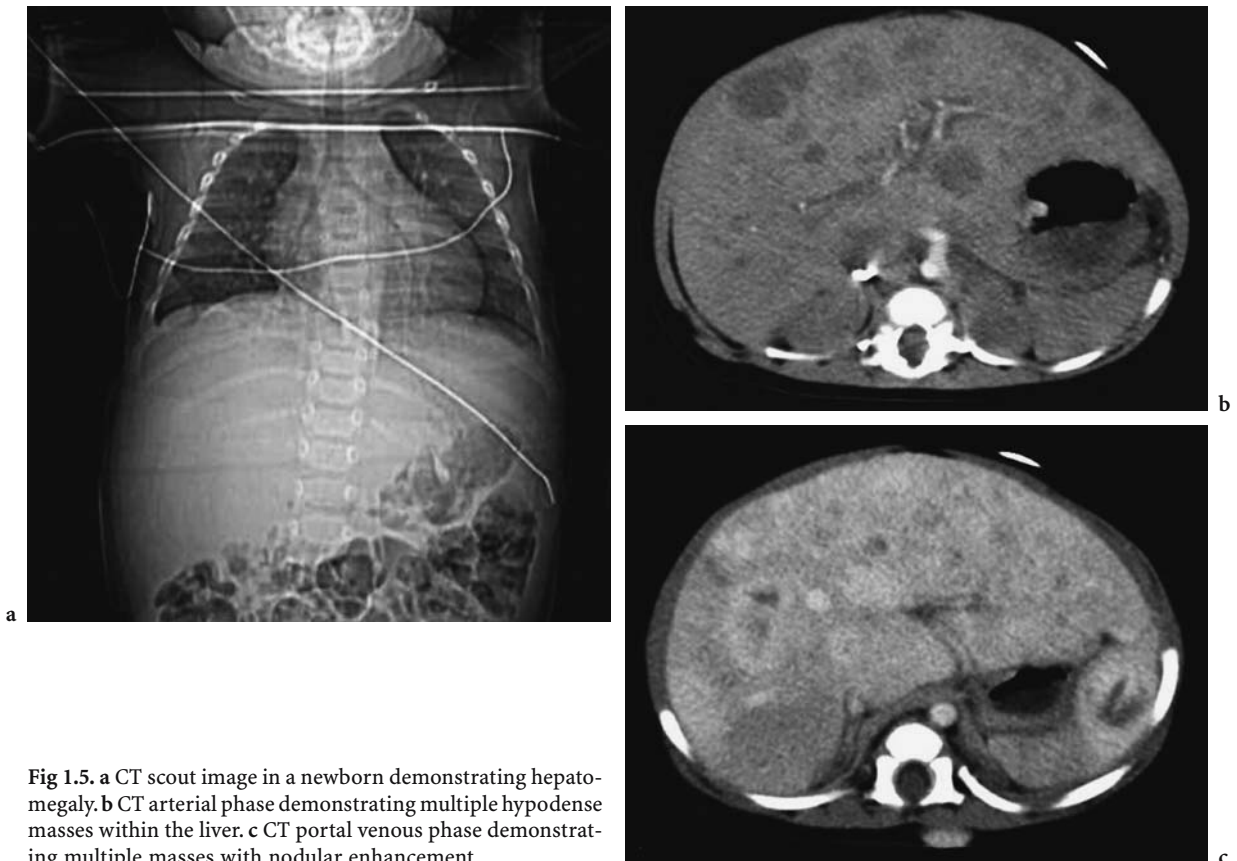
a CT scout image in a newborn demonstrating hepatomegaly. b CT arterial phase demonstrating multiple hypodense masses within the liver. c CT portal venous phase demonstrating multiple masses with nodular enhancement
